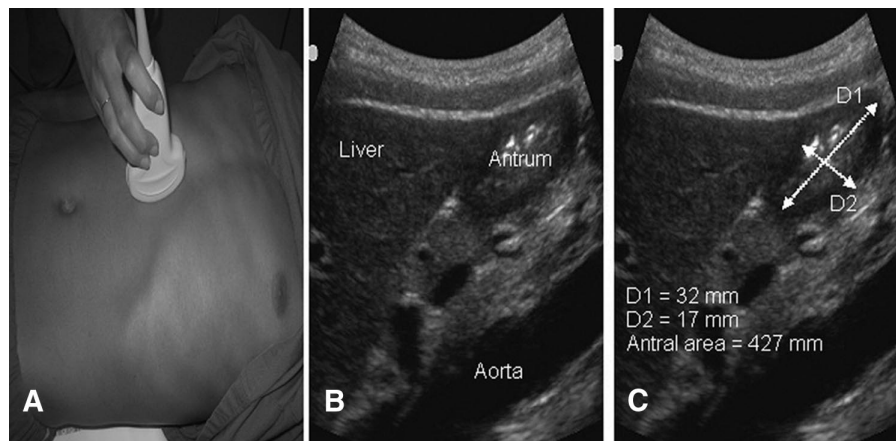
(A) Transducer position to scan the gastric antrum. (B) Example of a gastric ultrasonographic image. (C) Example of measurement of the antral area.
